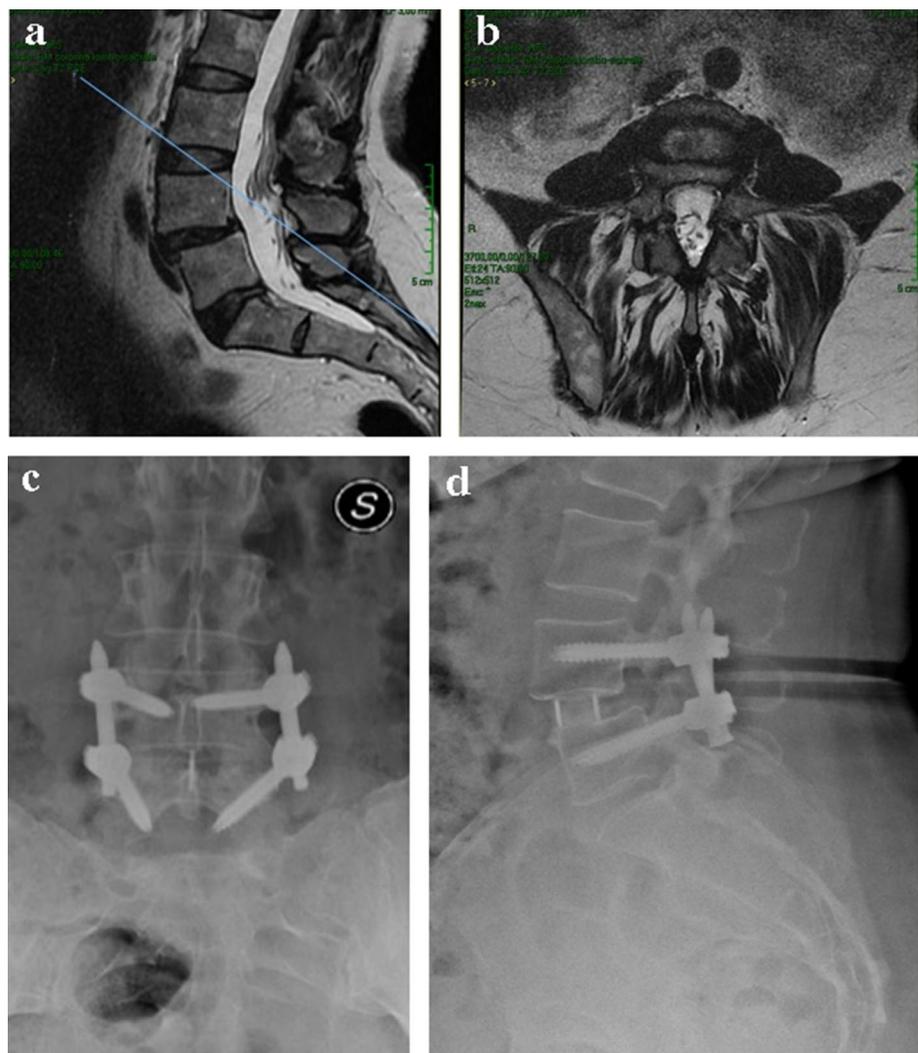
a, b MRI images of a 54-year-old female with L4 and L5 isthmic spondylolisthesis without narrowing of the spinal canal or roots compressions at the slipped level. c, d Postoperative a-p and lateral view X-rays show the correct placement of pedicle screws and PEEK cage between L4 and L5. On lateral view, a quite complete correction of the olisthesis is appreciable. The position of the cage results more anterior than the normal respect to the end plate of the caudal vertebra although it is perfectly positioned respect to the lower end plate of the slipped vertebra. It depends to the choice of the entry point to the intervertebral disc that, in case of spondylolisthesis, can be more anterior than the normal due to the position of the neurological structures and the femoral nerve in particular
